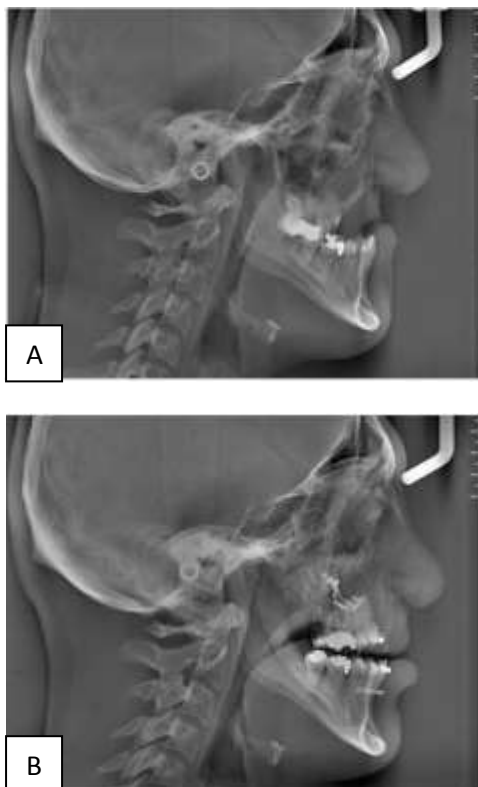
Lateral cephalometric radiograph of the patient: (A) Before orthodontic treatment and distraction osteogenesis. (B) After distraction osteogenesis.
